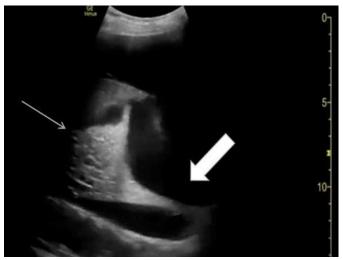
Point-of-care ultrasound in sagittal view of the left hemithorax showing a large, septated pleural effusion (thick arrow) with compressive atelectatic lung (thin arrow).
